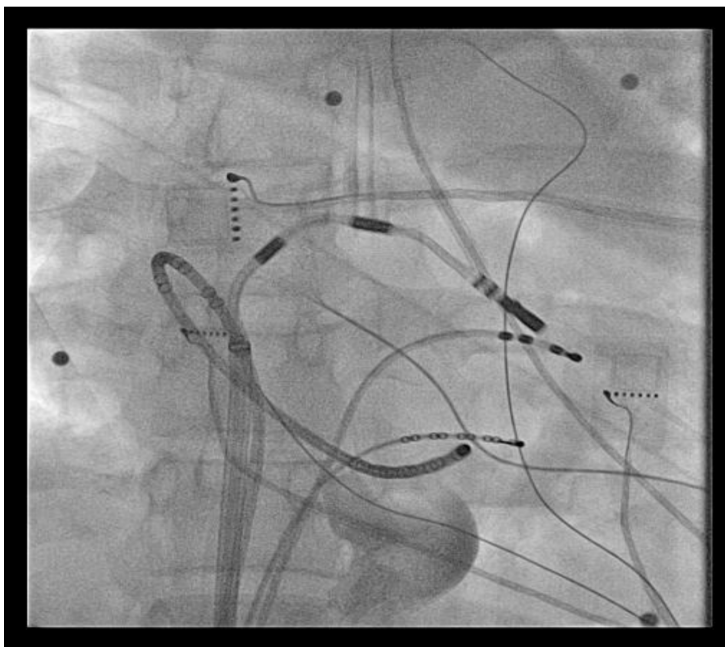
X-ray thorax: RMT ablation catheter in the LA, aligned left laterally
